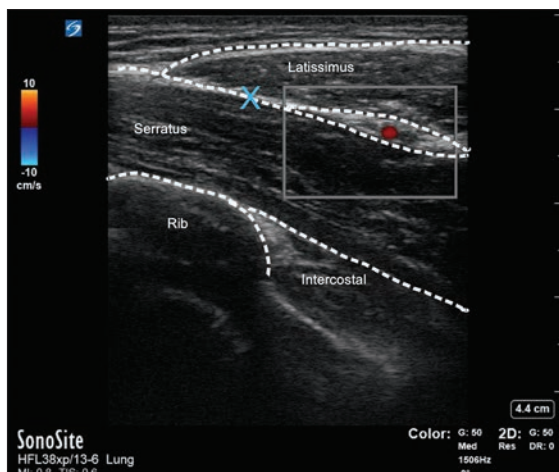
Ultrasound visualisation of the latissimus dorsi and serratus anterior. Colour Doppler has been used to locate the thoracodorsal artery, which appears as a red spot in the photo. A blue X marks the superficial fascial plane.
